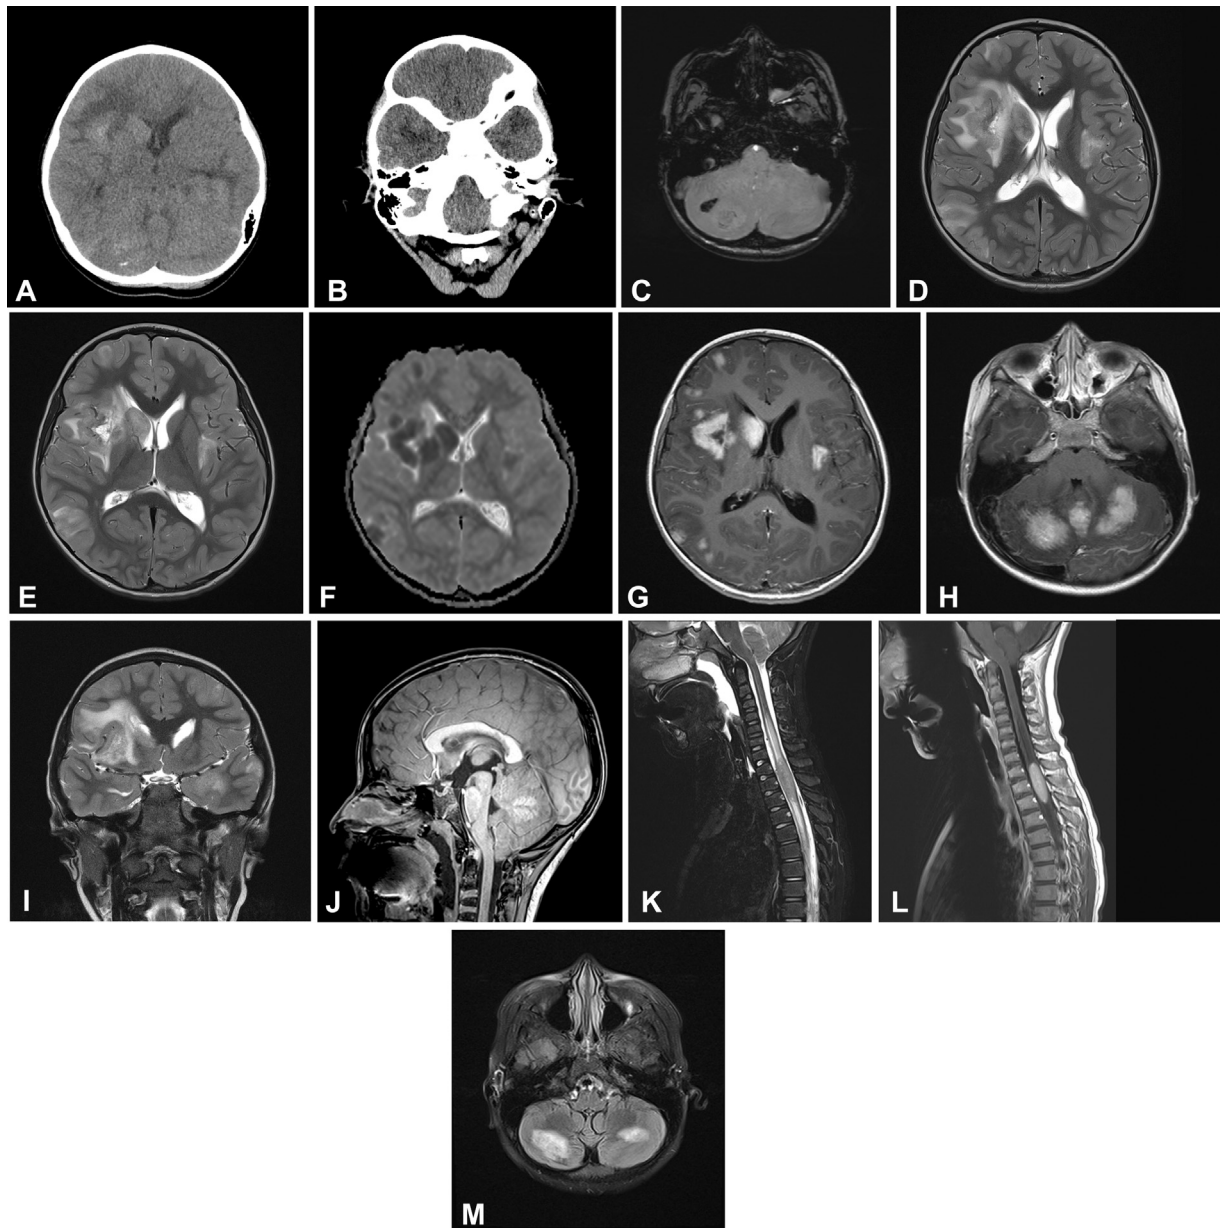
5-year-old with AHLE. (A) Axial noncontrast CT shows confluent hypodense lesions in the cerebrum and cerebellum. There is focal increased density of the right frontal lobe. Punctate focus of increased density is seen of the right cerebellar hemisphere, likely related to hemorrhage. (B) Axial noncontrast CT shows effacement of the basal cisterns at the level of the foramen magnum. (C) Axial susceptibility weighted image shows a focus of hypointensity consistent with hemorrhage, corresponding to the increased density seen on CT. (D, E) Axial T2-weighted images show vasogenic edema of the bilateral cerebral hemispheres and right caudate head. Foci of relative T2-hypointensity are present within the regions of vasogenic edema. (F) Axial ADC image shows multiple foci of diffusion restriction involving the deep gray matter structures and cerebral cortex. (G, H) Gadolinium enhanced axial T1-weighted images shows multiple foci of enhancement within the infratentorial and supratentorial brain corresponding to the regions of relative T2 hypointensity and diffusion restriction. (I) Coronal T2-weighted image shows edema involving the intracranial optic nerves. (J) Sagittal T1-weighted image shows effacement of the basal cisterns at the level of the foramen magnum with dilatation of the cerebral aqueduct and inferior recesses of the third ventricle. (K) Sagittal T2-weighted and (L) sagittal gadolinium enhanced T1-weighted images of the upper spinal cord show an oval lesion similar to those seen intracranially associated with marked enhancement and adjacent extensive vasogenic edema. ADC, apparent diffusion coefficient; AHLE, acute hemorrhagic leukoencephalitis; CT, computed tomography.
